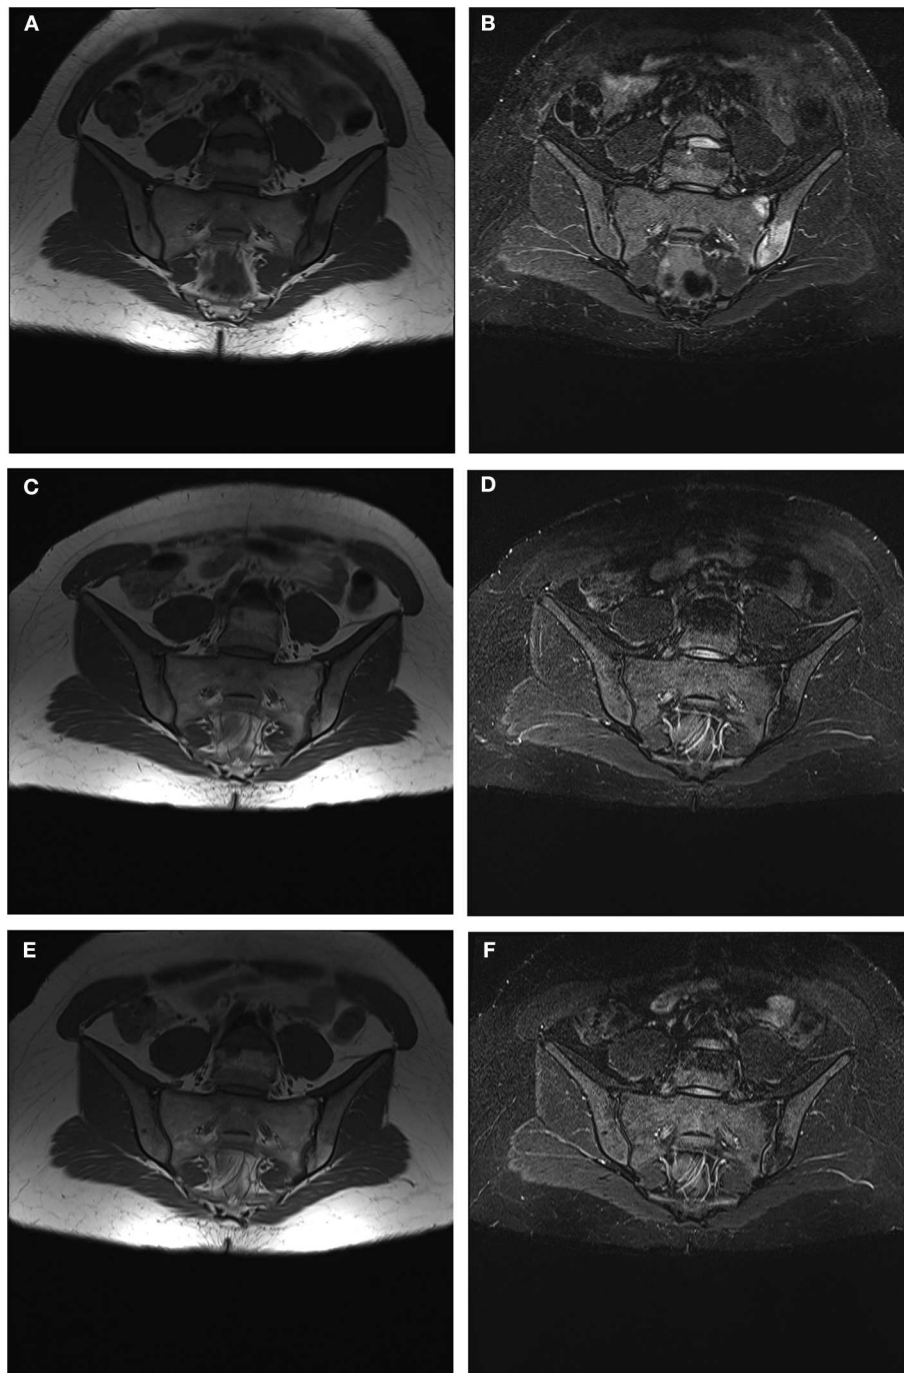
(A–F) Progressive reduction until disappearance of BMO signs and subsequent corresponding appearance of signs of adipose metaplasia on left SIJ during a follow up period of 24 months. (A) MRI-SIJ at T0 in T1 sequence (B) MRI-SIJ at T0 in STIR sequence (C) MRI-SIJ at T12 in T1 sequence (D) MRI-SIJ at T12 in STIR sequence (E) MRI-SIJ at T24 in T1 sequence (F) MRI-SIJ at T24 in STIR sequence. The written informed consent was obtained from the individual for the publication of these images.
